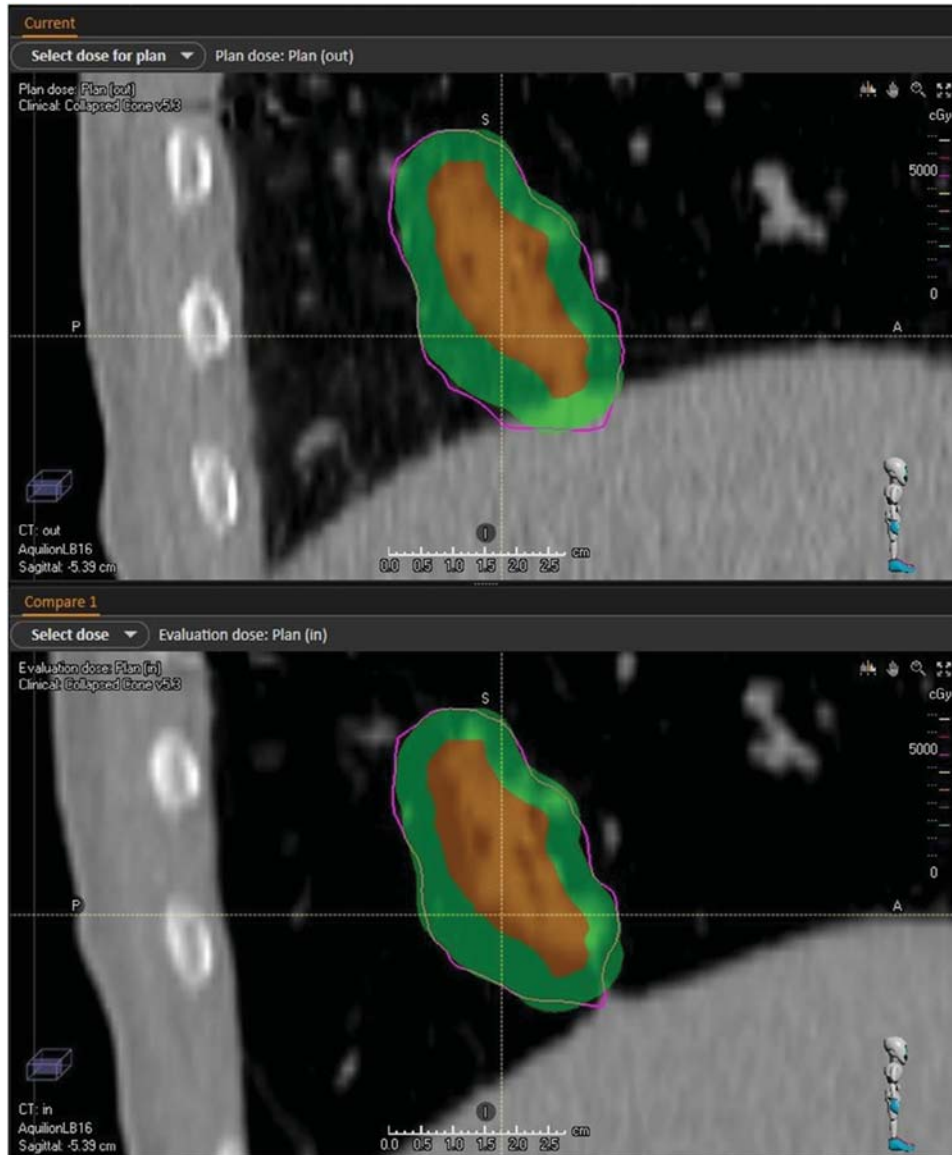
Example of the dose perturbation near the diaphragm. The upper part shows the planning dose distribution in the exhale CT, and the lower part shows the evaluation dose distribution in the inhale CT in real-time tumor tracking. Clinical target volume (solid red), planning target volume with a 5-mm margin (solid green), and the prescribed isodose line (solid magenta) are shown in the figures.
